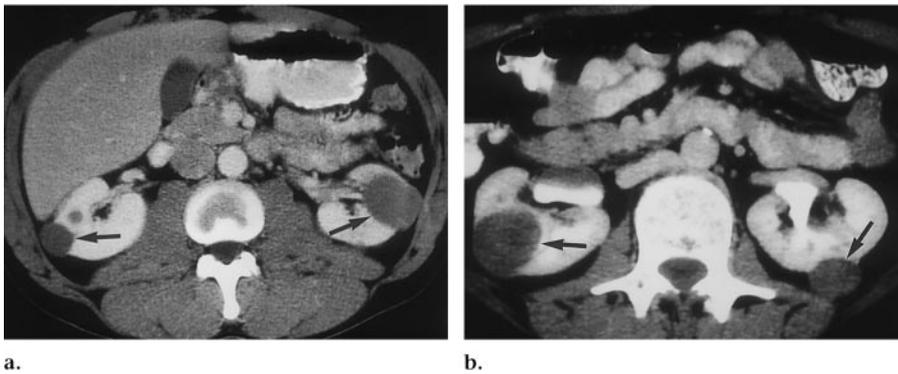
Hereditary papillary renal cancer. Transverse CT images demonstrate bilateral papillary renal cancers (arrows) in (a) a mother and (b) her son. The tumors are characteristically poorly enhancing and might be confused with cysts. Careful enhancement measurements may be necessary to be certain that the lesions are enhancing. Papillary renal cancers are considered less vascular than other tumor types.
